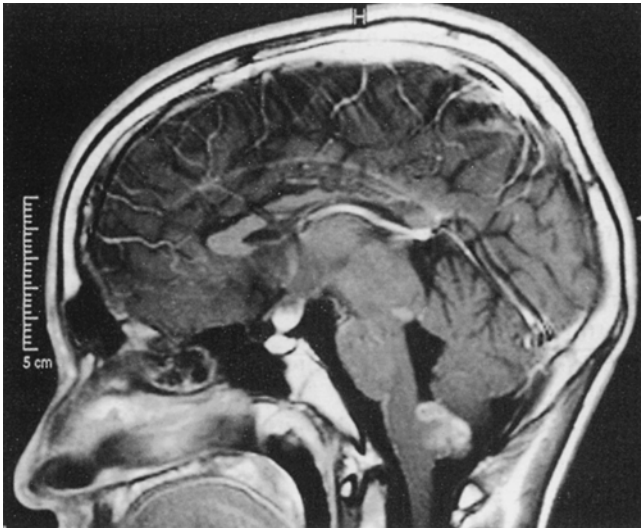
Sagittal T1-weighted MRI with gadolinium showing an exophytic enhancing tumor arising off the medulla. Note also, the tectal plate tumor (with a small area of enhancement) and the enhancing hypothalamic tumor. This 12-year-old boy had presented with hydrocephalus 5 years earlier and on the basis of the CT scan performed at that time, the diagnosis of hydrocephalus secondary to aqueduct stenosis was made. Although asymptomatic, further imaging of the spine revealed another tumor (Fig. 25.9)
